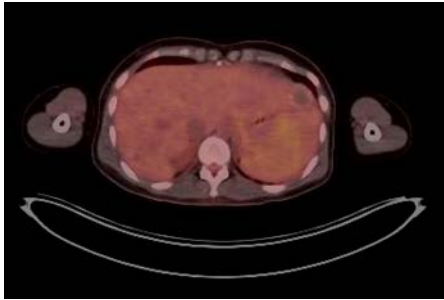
Abdominal PET/CT, notable for several liver lesion
